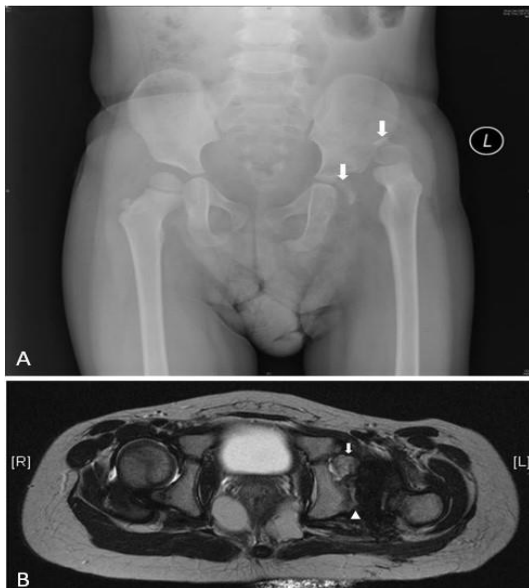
(A) Pelvic radiograph showed the left posterior hip dislocation. An extra-articular bone fragment (upper arrow) and an intra-articular bone fragment (lower arrow) were visible; (B) MRI of the left hip showed the posterior acetabular fracture (arrowhead) and an intra-articular bone fragment (arrow)
